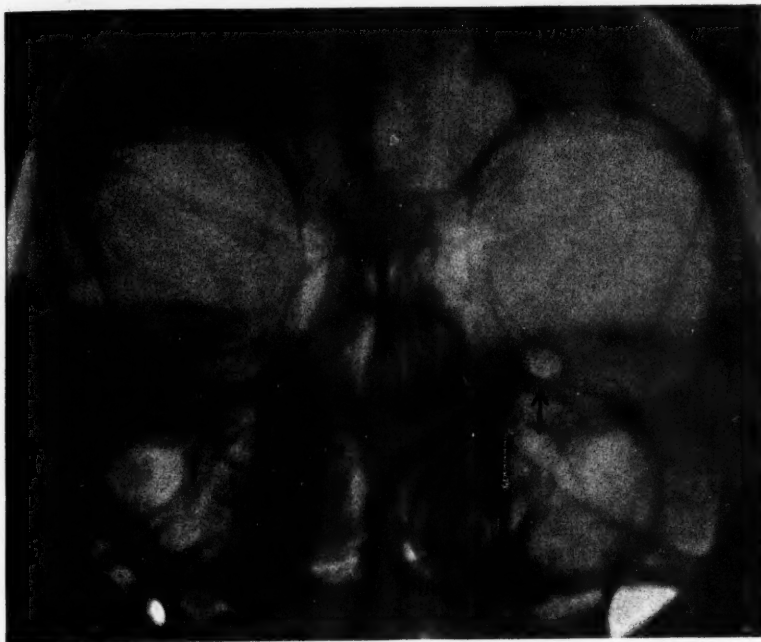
Postero-anterior roentgenogram of the base of the cranium. Right-sided dilatation of the foramen rotundum in tumor of the middle fossa.
